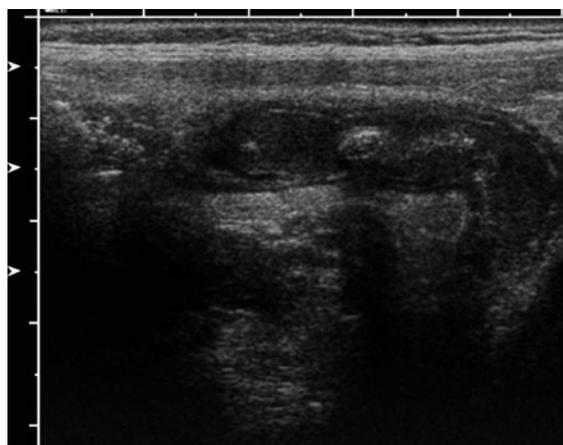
Phlegmonous appendicitis. Sonography shows a completely visualized thickened appendix with an appendicolith; a peri-appendiceal fat infiltration is also observed
